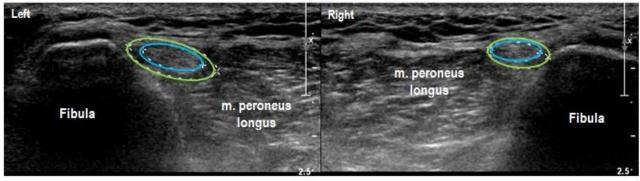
Ultrasound case 2: On the left side *n. fibularis communis* appeared hypoechoic, in comparison to the contralateral leg.
